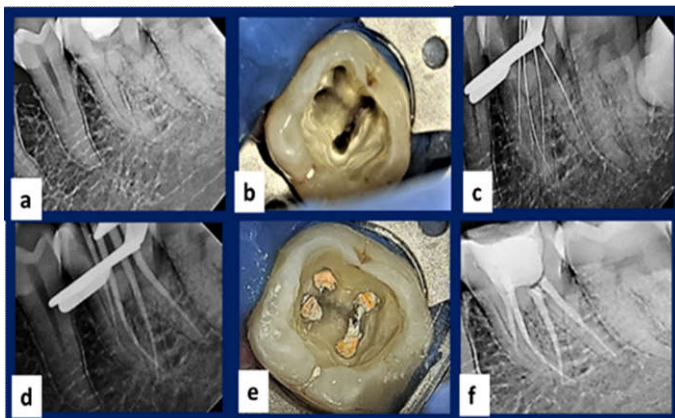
Pre op radiograph. b) Access opening. c) Working length determination radiograph d) Master cone selection radiograph. e) Obturation clinical view. f) Post obturation radiograph
